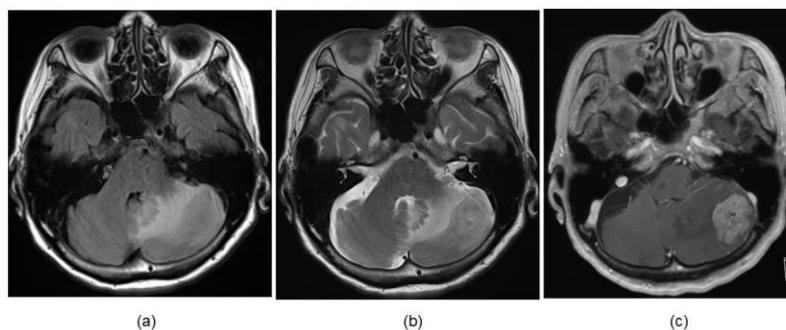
Magnetic resonance imaging of the head on the axial section displayed the round tumor located at the right cerebellar hemisphere as iso-intensity on T1-weighted image (a) and hyper-intensity on T2-weighted image indicating extensive surrounding edema (b) with diffuse and heterogenous enhancement after gadolinium administration.
